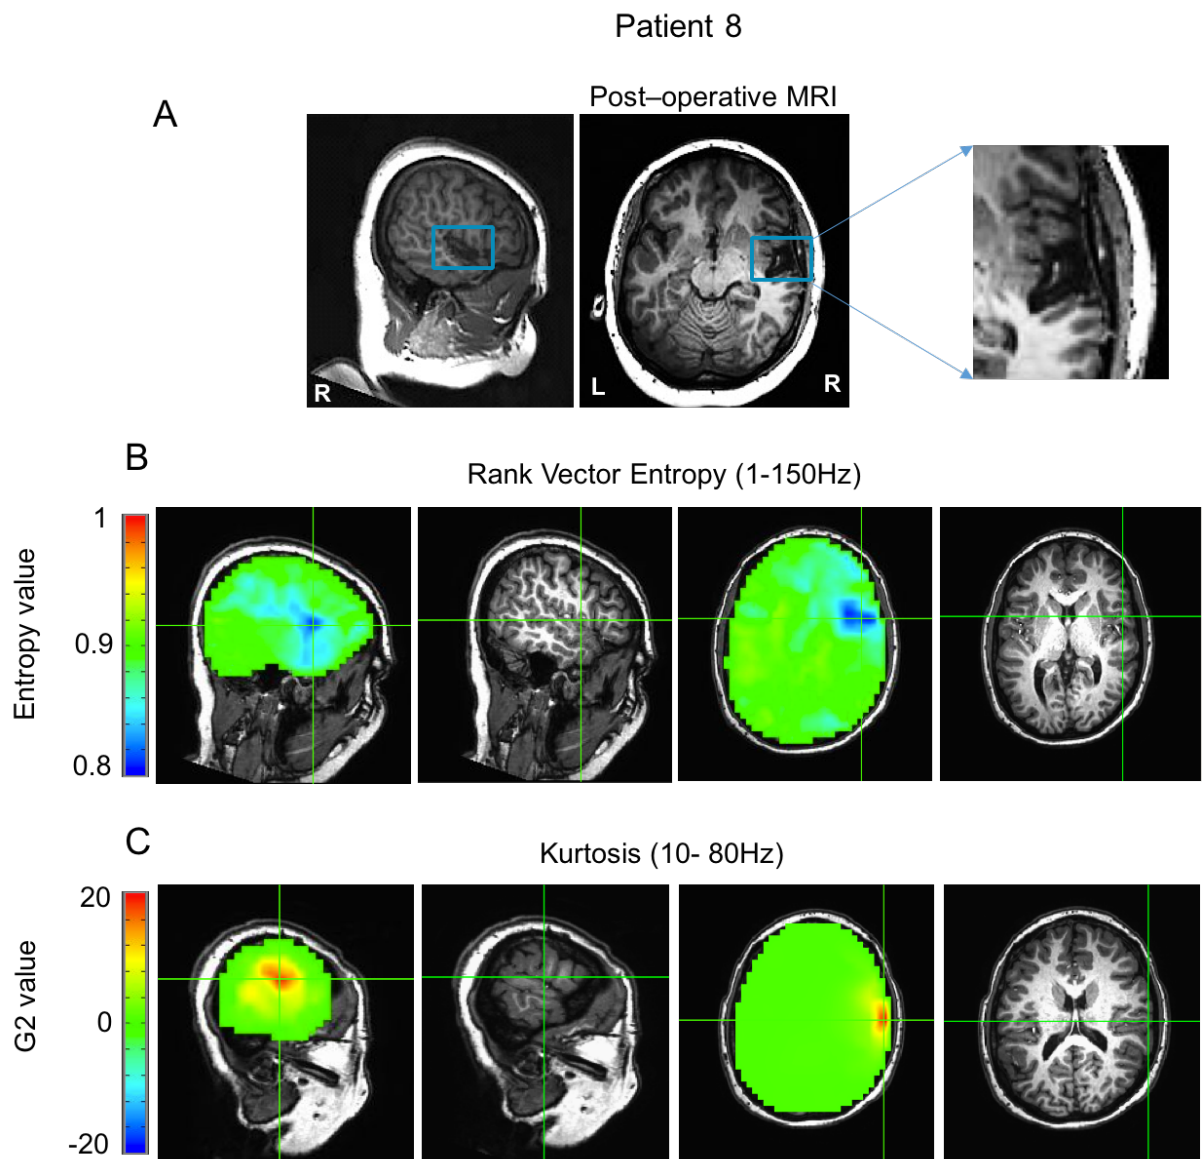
A comparison between the presurgical RVE and kurtosis beamformer localisations and subsequent resection area in a seizure free patient (at 12 months). (A) Post-operative MRI with the frontotemporal resection area indicated by the blue box. (B) RVE volumetric image at the time point showing the lowest RVE value plotted. (C) The kurtosis beamformer (10-80Hz) peak localisation.
